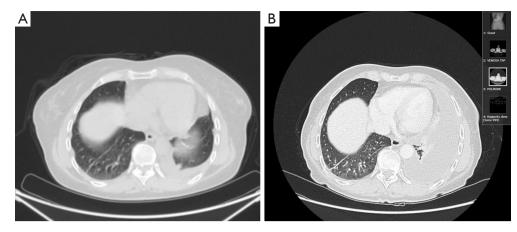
Case 2 CT scan of the chest. Pleural progression during front-line treatment with osimertinib. (A) Baseline disease. (B) Disease progression after 12 weeks of therapy. CT, computed tomography.
